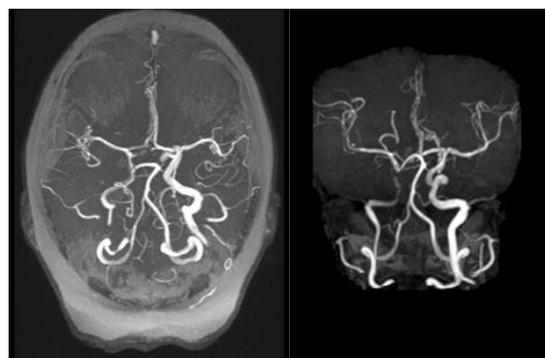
CT Angiogram of patient
